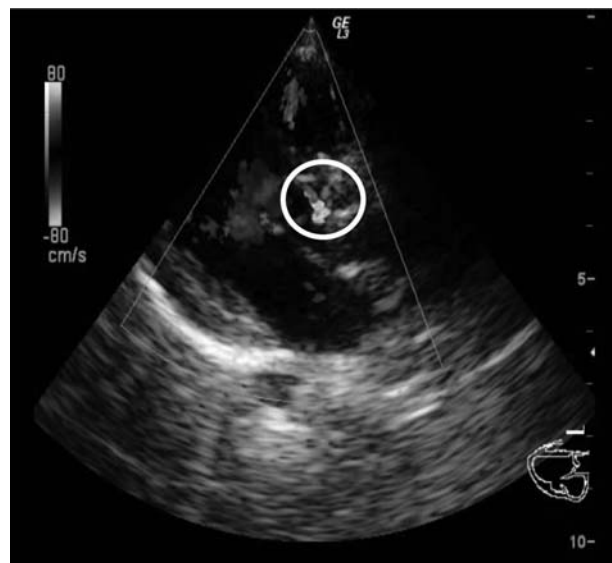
Echocardiography pre catheterization showed small trabecular muscular VSD.
